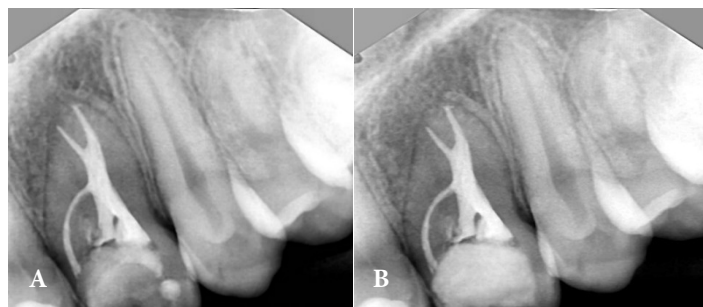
A) Postoperative periapical radiograph showing root canal obturation; B) 12-month follow-up radiograph
